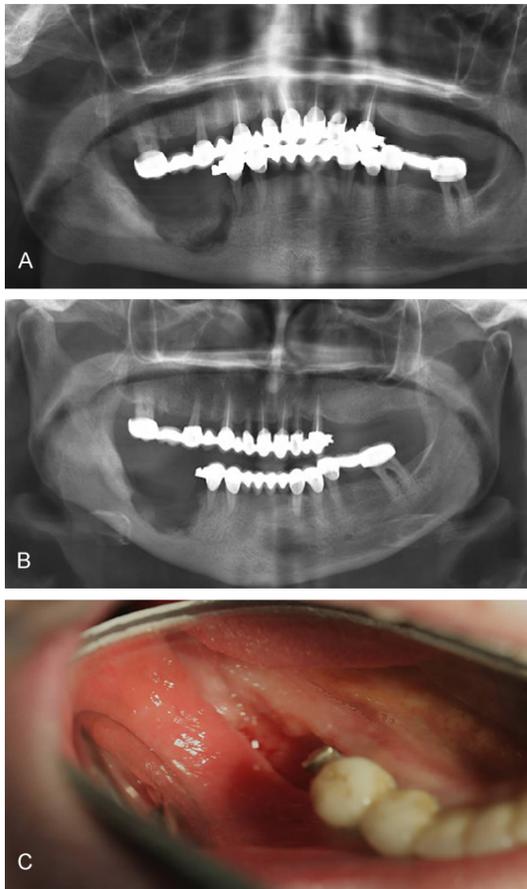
Stage three lesion in a patient with medication related osteonecrosis of the jaws. A. Radiographic image before sequestrectomy, B. Radiographic image taken two weeks after sequestrectomy, C. Intraoral image taken two weeks after sequestrectomy.
